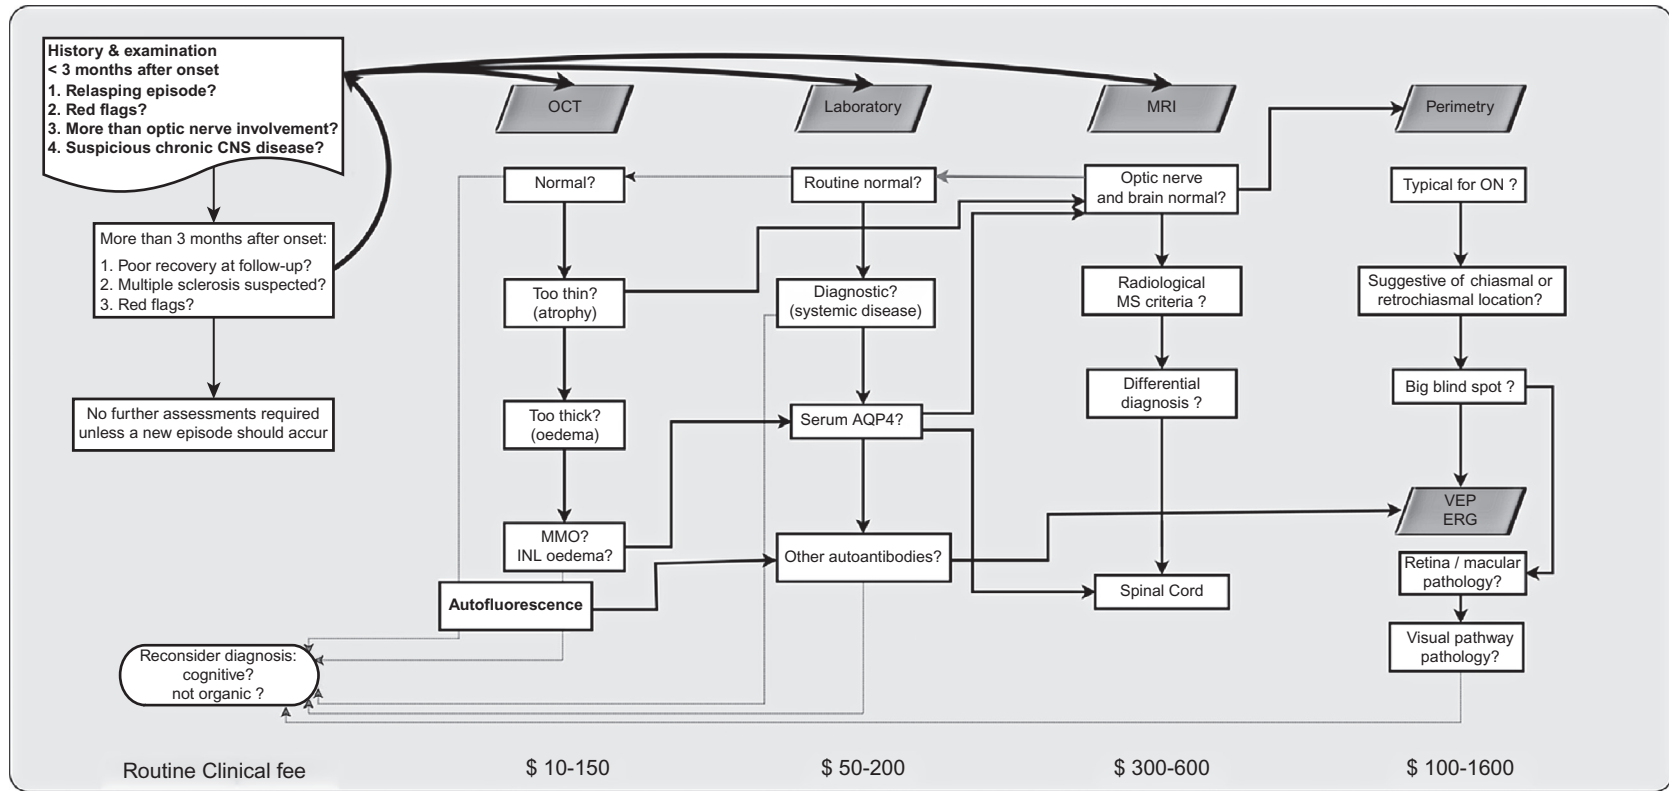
Diagnostic workup for patients presenting with autoimmune visual loss. The clinical decision on whether or not a patient requires further investigations depends on key points from the history and clinical examination. The approximate costs in US dollars (\$) related to escalation of investigations are given for general guidance only, as fees vary substantially between institutions. The clinical decision tree emphasizes pertinent questions, pointing horizontally for “yes” (closed lines) and vertically for “no” answers (dotted lines). CNS, central nervous system; OCT, optical coherence toography; MRI, magnetic resonance imaging; MMO, microcystic macular edema; INL, inner nuclear layer; AQP4, aquaporin-4; MS, multiple sclerosis; ON, optic neuritis; VEP, visual evoked potential; ERG, electroretinography. (Modified from [Petzold et al., 2014.](#))
